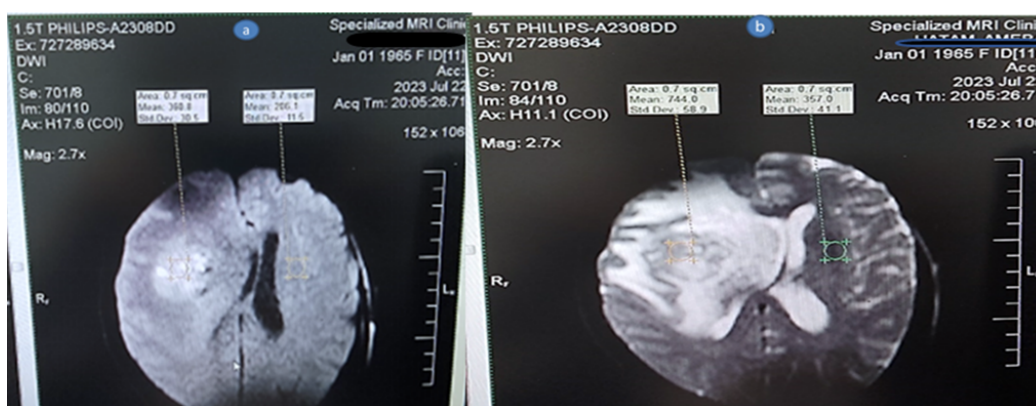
shows the a) Axial DWI image, and b) Axial ADC image. The patient had a tumor located in the Rt. The temporal lobe, which was diagnosed as glioblastoma grade IV, shows hypointensity on the T1-weighted image. The DWI showed an isointense tumor compared with the normal part, and the ADC showed hyperintensity of the tumor.
